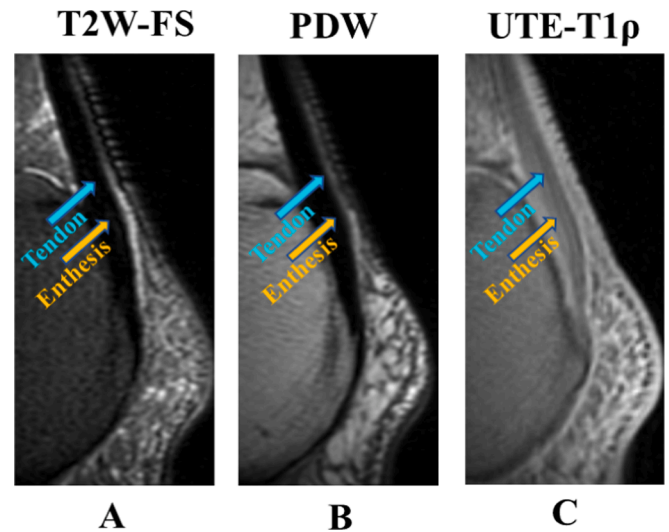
(A) FS T2W-FES (B) PDW FSE (C) 3D UTE-T1 ρ images of the ankle for an asymptomatic 35-year-old male volunteer. Note that the Achilles tendon (blue arrow) and enthesis (yellow arrow) show no signal on conventional clinical MRI images (A and B). On the 3D UTE-T1 ρ image, the enthesis is evident as a region with a higher signal between the Achilles tendon and calcaneus (C). FS, fat-suppressed; FS T2W-FES, FS T2-weighted fast spin echo; PDW, Proton-density weighted; 3D, three-dimensional; UTE, ultrashort echo time; UTE-Adiab-T1 ρ , UTE-adiabatic T1 ρ .
